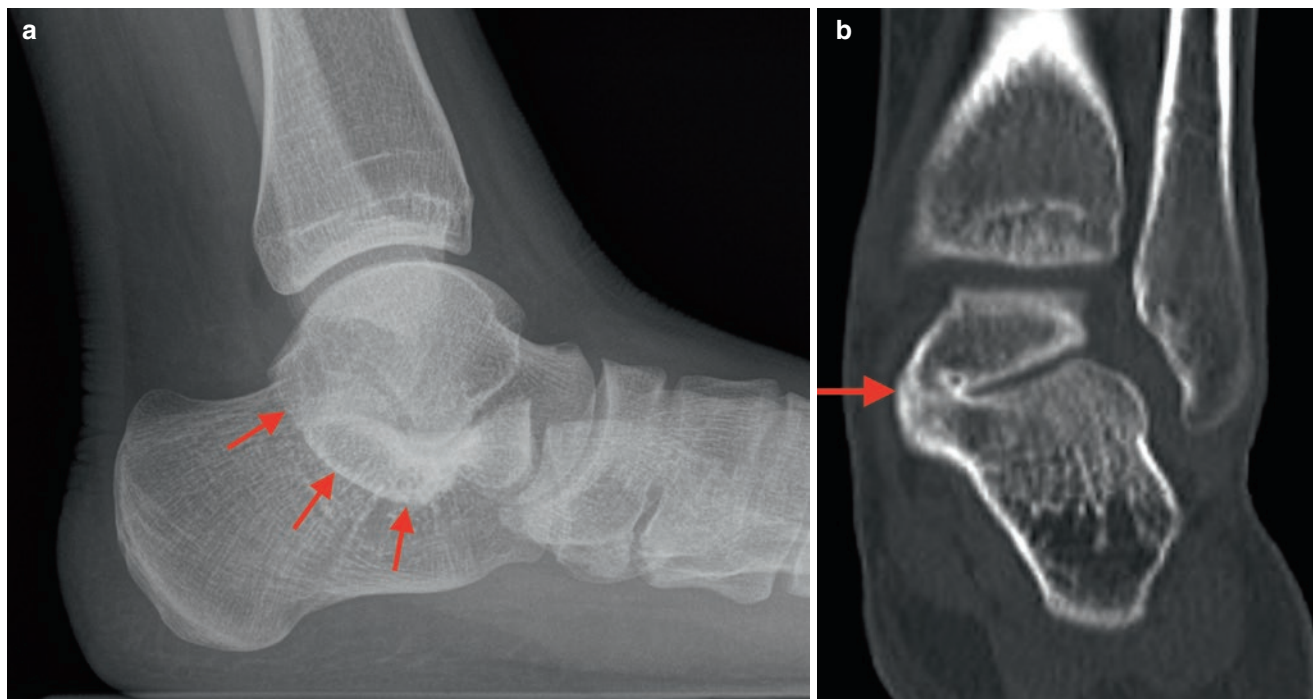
Talocalcaneal coalition. (a) Lateral radiograph demonstrates the “C” sign (arrows) due to coalition across the middle subtalar joint between talus and the sustentaculum tali of the calcaneus. (b) CT scan in the coronal plane demonstrates the bony coalition directly (arrow)
